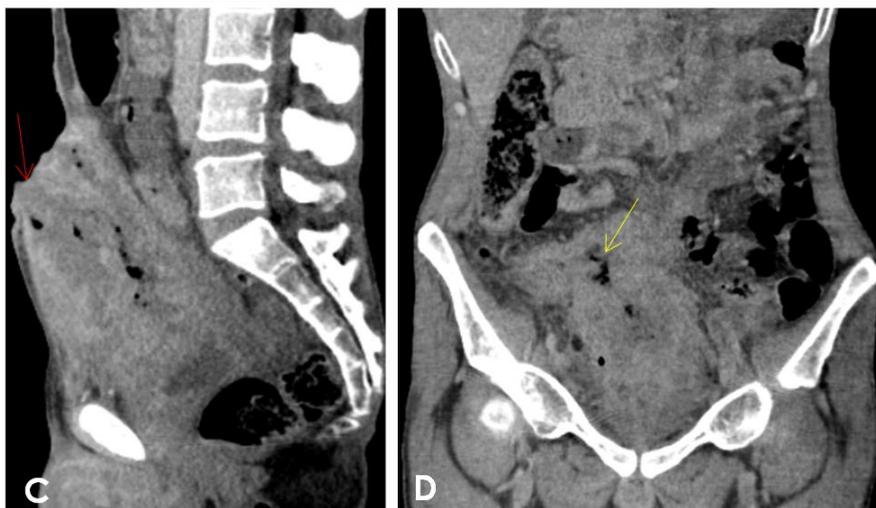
Axial (A, B), sagittal (C) and coronal (D) CT sections on portal venous injection demonstrating an heterogenous tumor between the umbilicus and the bladder protruding and infiltrating the skin surface of the peri-umbilical region, with cutaneous fistula (red arrow), and infiltration of the transverse colon with colo-Urachal fistula (yellow arrow)
